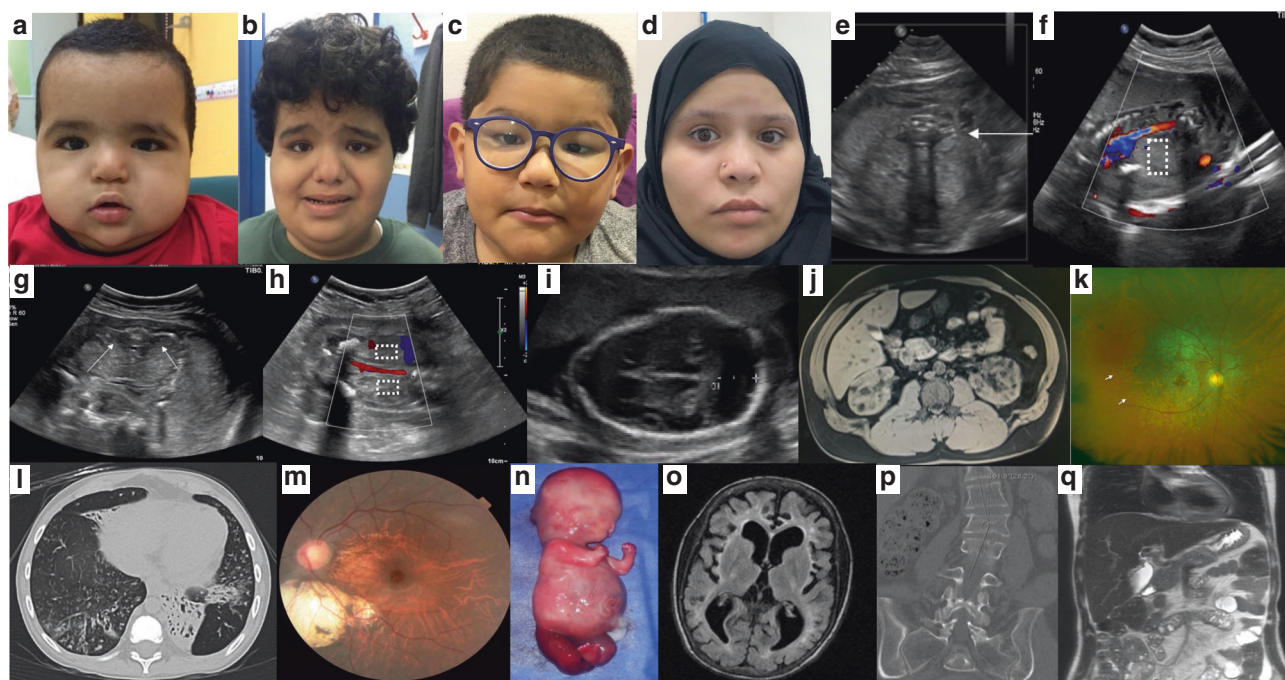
Clinical images of unusual phenotypes observed in this cohort. (a–c) Facial images of three Bardet–Biedl (BBS) patients—16DG0944 (*BBS9*: NM_198428.3:c.1789+1G>A), 19DG2152 (*BBS9*:NM_024649:c.363C > A;p.(Tyr121*)), and 19DG2175 (*BBS7*:NM_018190:c.1217_1218del:p.(Asn406-Serfs*6)), respectively—with the atypical feature of macrocephalic overgrowth. (d) *SCLT1*-related BBS (17DG1007 with *SCLT1*:NM_144643.2:c.290+2T > C:p.[Lys79Valfs*4]). (e, f) Antenatal ultrasound of *TTC21B*-related renal agenesis (17DG0098 with *TTC21B*:NM_024753.4:c.1176_1185+1del:p.[Lys393fs]), arrow points to empty renal fossa, indicating renal agenesis, and absence of the renal artery is indicated in (f) by dotted box. (g, h) Antenatal ultrasound of *NPHP3*-related renal agenesis (19DG0819 with *NPHP3*:NM_153240.4:c.2694-2_2694-1delAG), arrow points to empty renal fossa, indicating renal agenesis, and the absence of the renal artery is indicated in (h) by dotted boxes. (i) Antenatal fetal ultrasound showing atypical presentation of a fetus (16DG0393) homozygous for a pathogenic dominant variant *PKD1*:NM_000296:c.4349_4351del:p.(Asn1450del), showing enlarged posterior fossa and hypoplastic cerebellum. (j) Computed tomography (CT) scan for mother of 16DG0393 showing polycystic kidney and liver. (k) Atypical phenotypic expression of *WDR19* in a patient (19DG1441 with *WDR19*:NM_025132.4:c.2777G > T:p.[Ser926Ile]) with nonsyndromic Stargardt disease with a color fundus photo of the right eye showing chorioretinal atrophy in the central macula and residual flecks in the midperiphery (arrows). (l) An atypical BBS case (19DG0403 with *CEP164*: NM_001271933.1:c.1735C > T:p.[Arg579*]) with a phenotype of primary ciliary dyskinesia (PCD) in the lungs, and (m) color fundus photo of the left eye for the same patient showing macular atrophy, diffuse retinal pigment epithelial (RPE) atrophy, and chorioretinal coloboma. (n) An aborted fetus (19DG0238 with *TMEM231*:NM_001077416:c.597+1G > A and *CHRNA1*:NM_005199:c.1495C > T:p.[Arg499Trp]) with a blended phenotype of MKS and fetal akinesia. (o–q) A case (19DG1316) with a homozygous variant *INVS*:NM_014425:c.875C > T:p.(Pro292Leu), and a heterozygous variant *SUFU*:NM_001178133:c.1297-3C > A, images show brain atrophy, liver cirrhosis, and levoscoliotic deformity of the lumbar spine centered at L2 with Cobb angle of 28 degrees.
